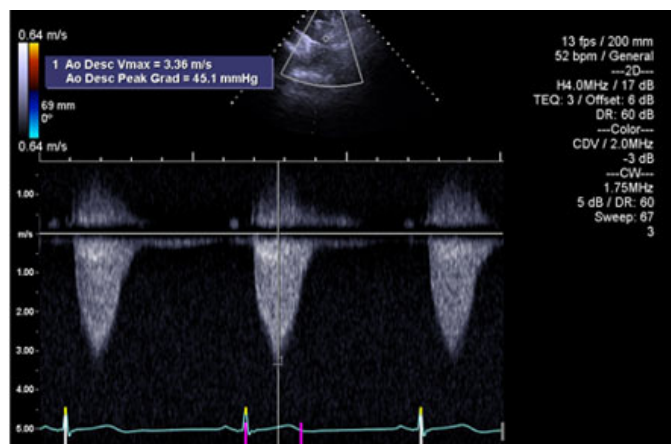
Echocardiogram confirming the diagnosis of pseudocoarctation of aorta with gradient of 45/23 mmHg.
